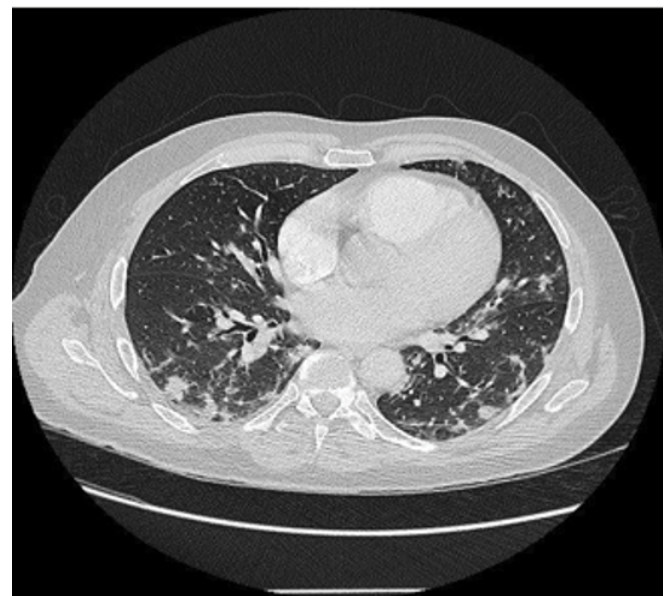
CT lung imaging.
